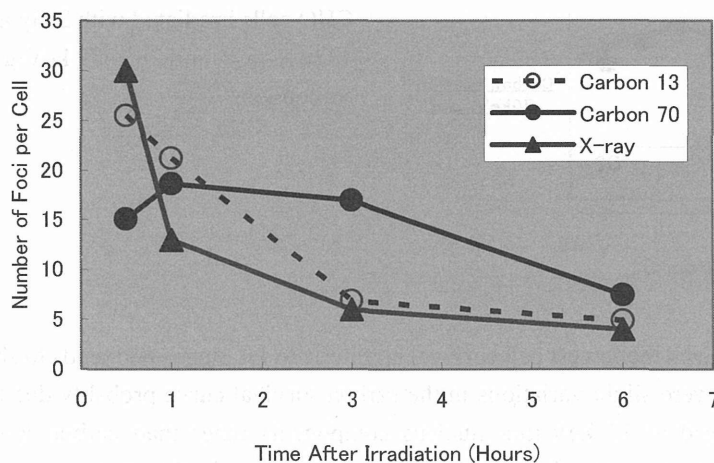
Kinetics of gamma-H2AX foci appearance/disappearance in human cells irradiated with 1 Gy X-rays, 13 keV/ $\mu\text{m}$  and 70keV/ $\mu\text{m}$  carbon ions.
